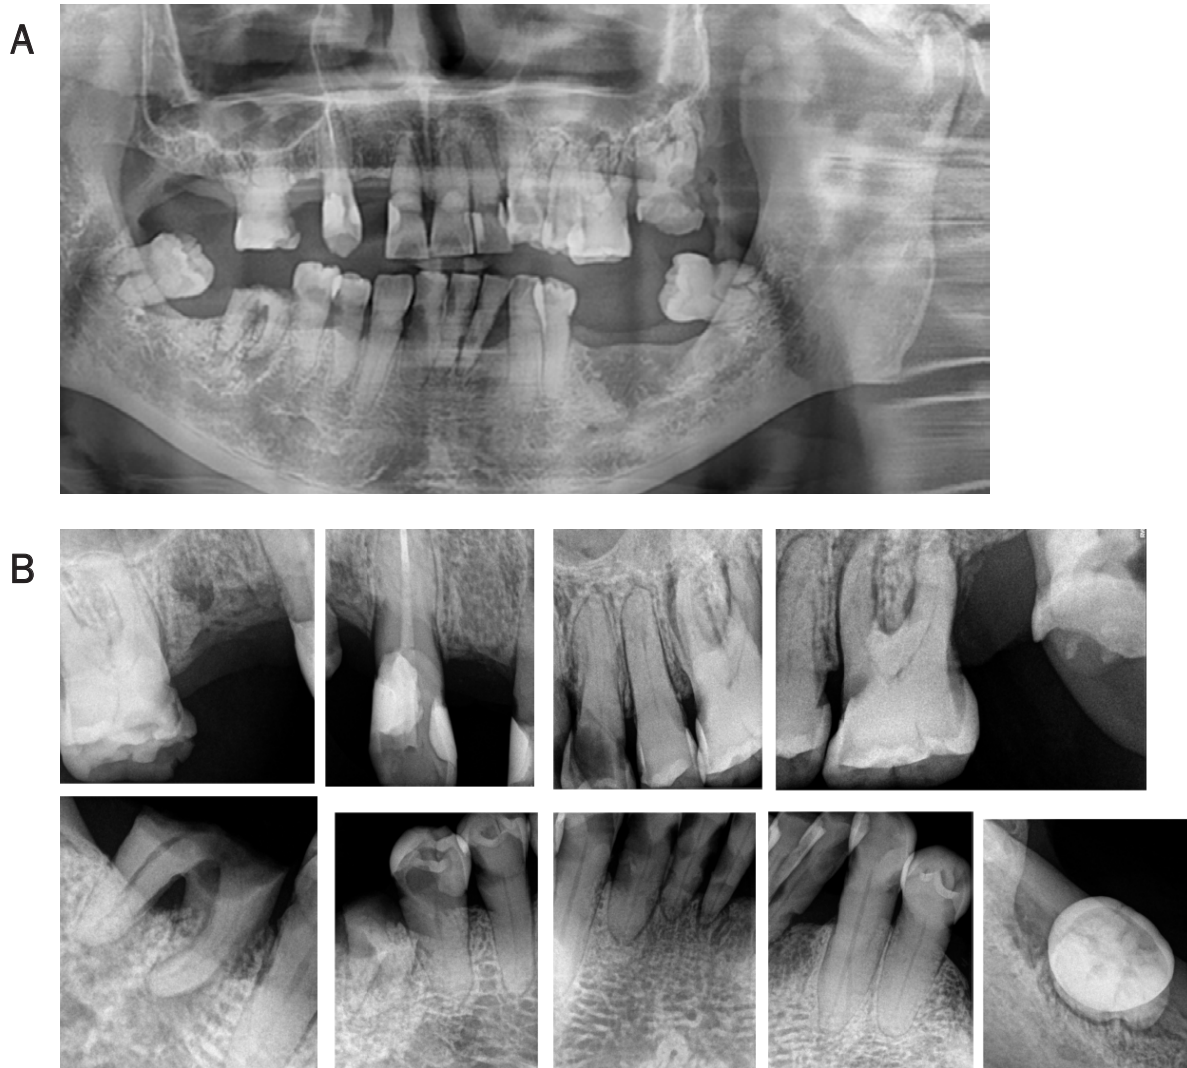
Pre-operative radiographic examination. (A) Panoramic view. (B) Periapical radiograph.
